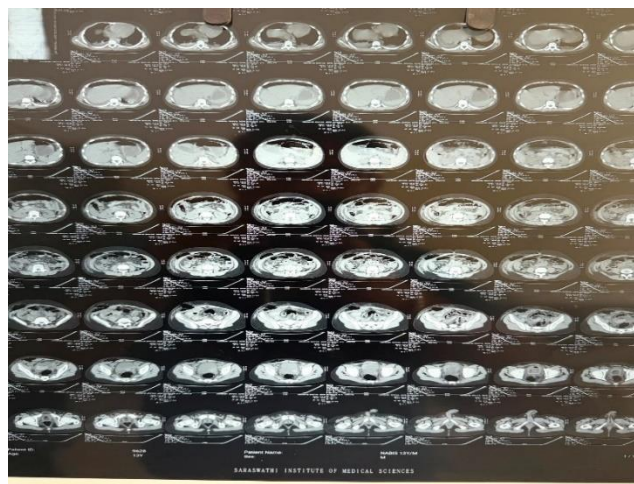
Contrast-enhanced CT abdomen showing pneumoperitoneum, distal ileal perforation, and hemoperitoneum.
